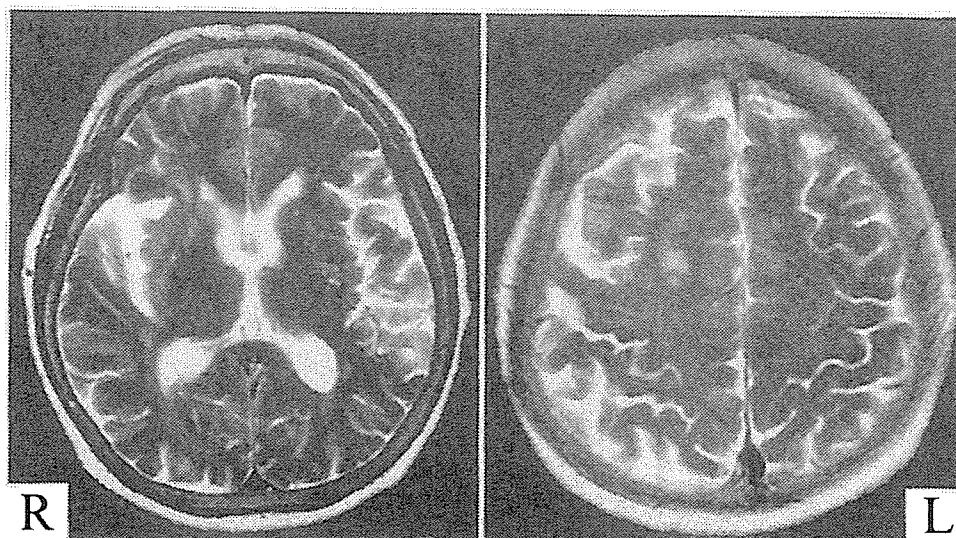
Case 2. Axial T₂-weighted MR images obtained at admission, showing small areas of high signal intensity in the right white matter in the frontal lobe and bilateral basal ganglia.
